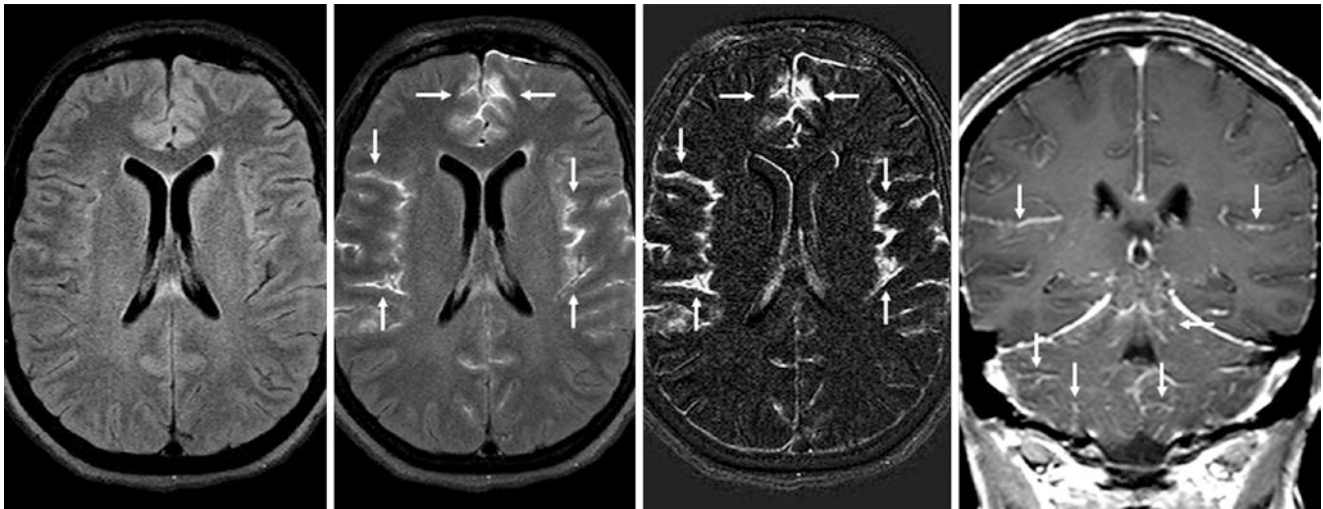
Comparison case of herpes simplex virus (HSV) meningitis. A 39-year-old HIV+ female with a fever and altered mental status had normal noncontrast FLAIR at 3T (*left*). However, postcontrast FLAIR (*left middle*) depicted true LMCE (*arrows*), confirmed by
